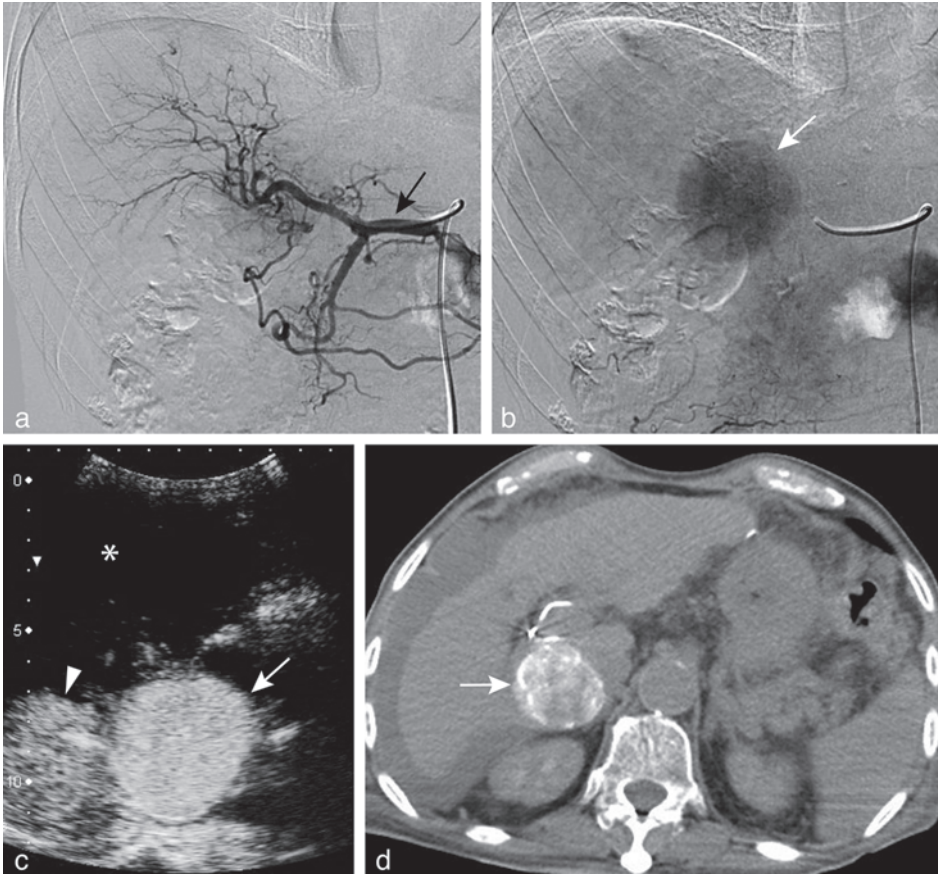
79-year-old man with a 4.5 cm HCC at the border of segment 6 and the caudate lobe. (a-b) DSA from the common hepatic artery (black arrow) in arterial (a) and parenchymal (b) phase with opacification of the tumor (white arrow). (c) CCEUS from the subsegmental artery showed complete tumor enhancement (white arrow) with enhancement of a small portion of non-tumorous liver parenchyma (arrowhead) and no enhancement of most of the right liver lobe (asterisk). (d) CTHA confirmed enhancement of the entire tumor upon injection of contrast into the subsegmental artery. CCEUS and CTHA thus ensured complete tumor targeting by injection of drug-eluting beads into the subsegmental artery. IVCEUS directly after treatment and CT at 6 weeks showed complete devascularization of the tumor (not shown).
